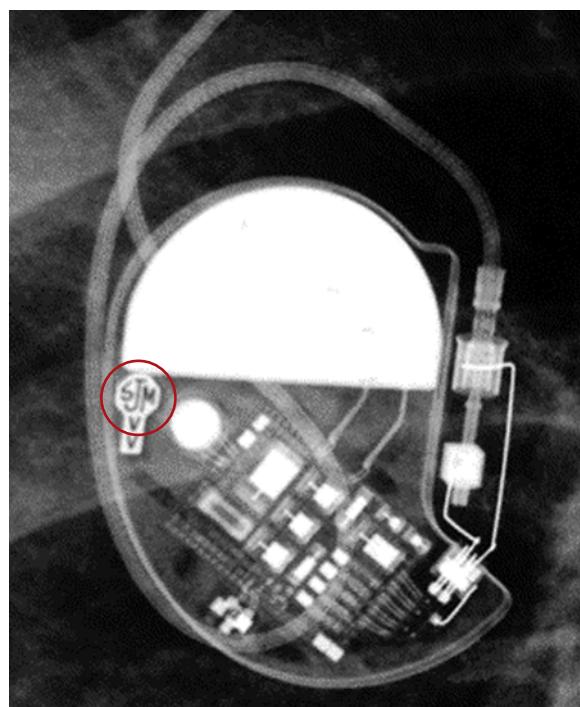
Chest radiograph of the cardiovascular implantable electronic device generator. The letter designation on the generator allows the physician to identify this manufacturer as St. Jude Medical.
